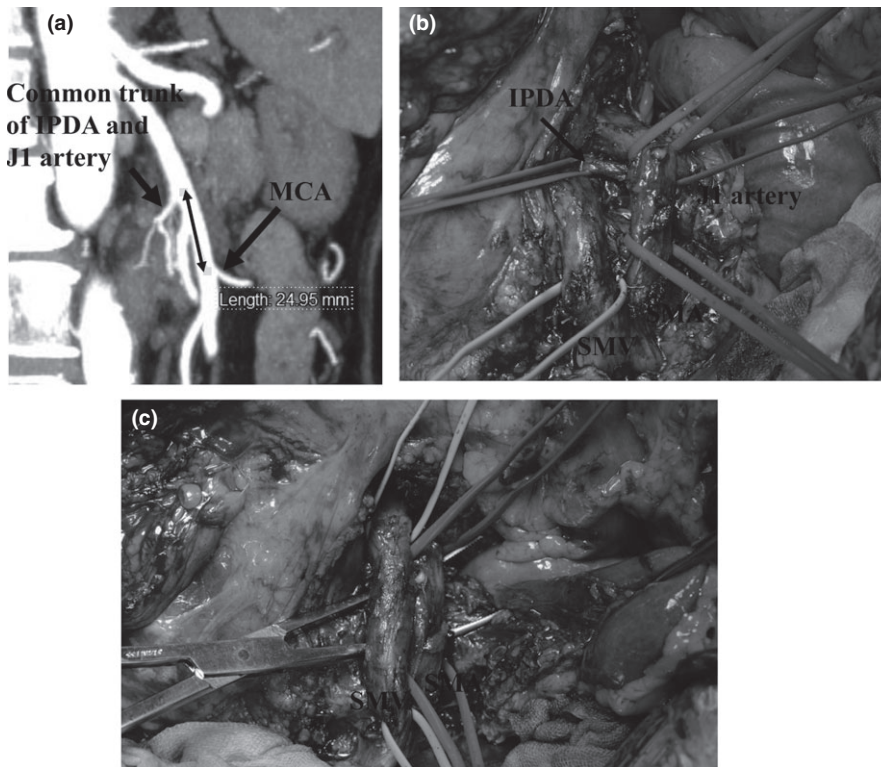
(A) Inferior pancreaticoduodenal artery (IPDA) anatomy was evaluated based on three-dimensional computed tomography (3D-CT) angiography. In this case, the common trunk was composed of IPDA and the first jejunal artery (J1 artery) arose from the superior mesenteric artery (SMA). In this case, the distance from the root of the middle colic artery (MCA) to the root of the common trunk of IPDA and J1 artery was approximately 25 mm based on 3D-CT. (B) During dissection of the connective tissue around the SMA, the root of the common trunk of IPDA and J1 artery was identified; it was then ligated and divided. (C) Completion of dissection of the connective tissue around the SMA and superior mesenteric vein (SMV).
